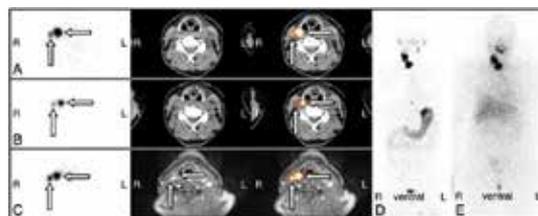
^{124}I PET/CT and ^{124}I PET/MRI in initial staging. A: axial ^{124}I PET/CT (after 24 h). B: axial ^{124}I PET/CT (after 96 h). C: axial ^{124}I PET/MRI (after 24 h). D: ^{124}I PET MIP (after 24 h). E: Whole-body scan after RIT with 7.0 GBq ^{131}I (after 8 days). 47-year-old female patient with a papillary thyroid carcinoma (pT3 pN1a), 4 weeks after thyroidectomy. The arrows mark two lymph node metastases right cervical. On images D and E, cervical lymph node metastases and thyroid remnant tissue are visible. The blood dosimetry revealed a MTA of 18 GBq ^{131}I , until the blood dose of 2 Gy is reached. The lesion dosimetry estimated a LDpA ranging from 12 to 120 Gy/GBq ^{131}I .
